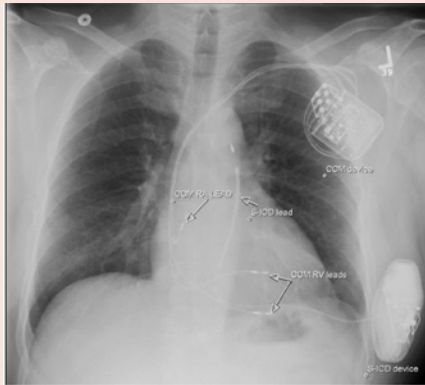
Posteroanterior (PA) chest X-ray view of a patient with subcutaneous ICD (S-ICD) and Cardiac Contractility Modulation (CCM) devices and leads.
